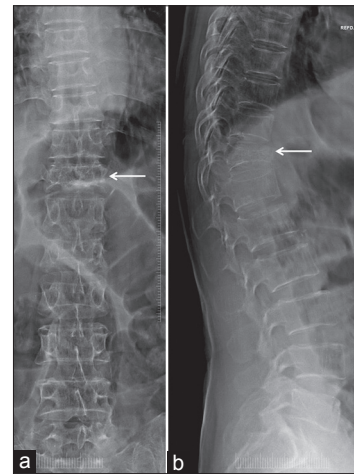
Lateral radiograph of spine shows characteristics of osteoporotic fracture. Severe/grade 3 fracture noted in D11 vertebra (arrow). Other vertebrae show prominent vertical trabeculae and sharply outline cortical end-plates
